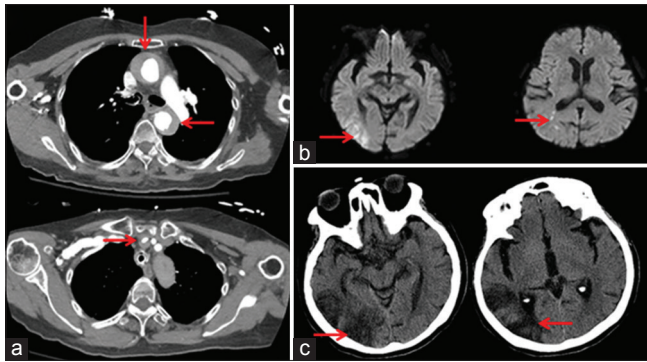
(a) Computed tomography chest with contrast showing a false lumen (arrows) in the ascending and descending aorta (upper image) and right common carotid (lower image) consistent with dissection. (b) Magnetic resonance imaging diffusion-weighted images of the brain showing diffusion restriction in the right temporoparietal regions consistent with recent ischemia. (c) Computed tomography scan of the head after 30 days showing evolving hypodensities in the right temporoparietal areas consistent with subacute/chronic ischemia
